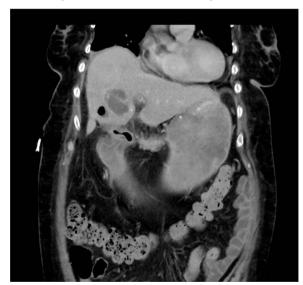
CT scan identified a stone between the first and second portion of the duodenum, gallstone ileus and cholecystoduodenal fistula.
